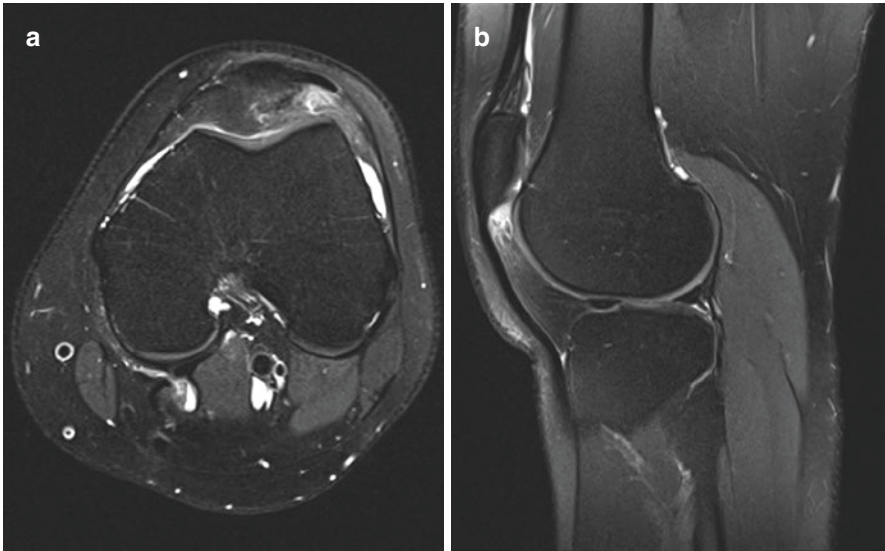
MR images (PD tse fs) in transversal (a) and sagittal (b) axis demonstrating areas of infrapatellar fat pad hyperintensity at the superolateral aspect and accompanying hoffa synovitis
